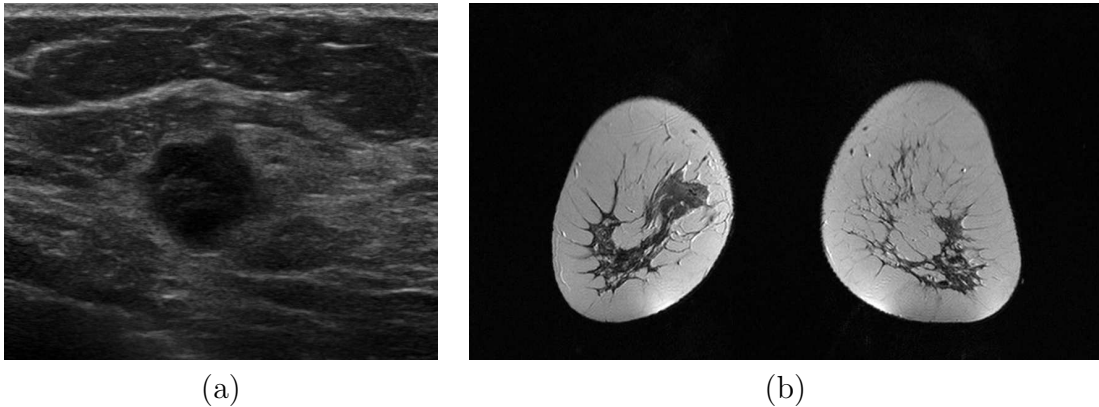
Example of breast imaging techniques: (a) breast US, and (b) breast MRI.
